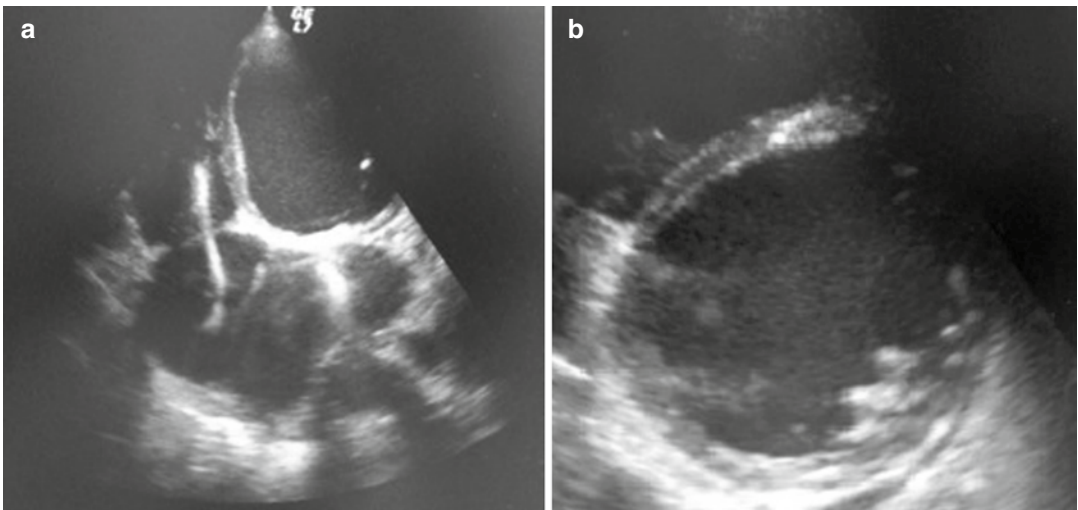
Echocardiographic images: apical four-chamber view (a) and parasternal short axis at papillary level (b) showing chamber dilation, mitral valve prosthesis, and presence of lead in right chambers
